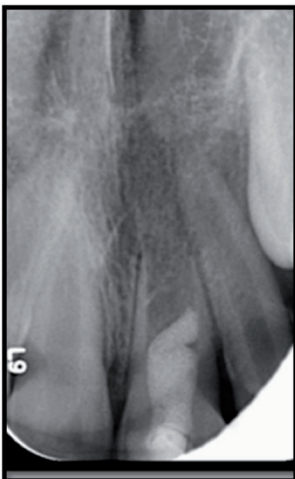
X-ray taken after 6 months.
